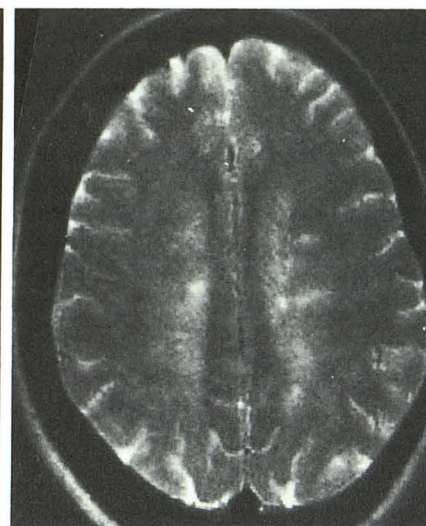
Case 3: 37-year-old woman with extremity weakness, photophobia, and systemic sarcoidosis. MR image, 2000/20 (TR/TE), shows periventricular and subcortical lesions.
